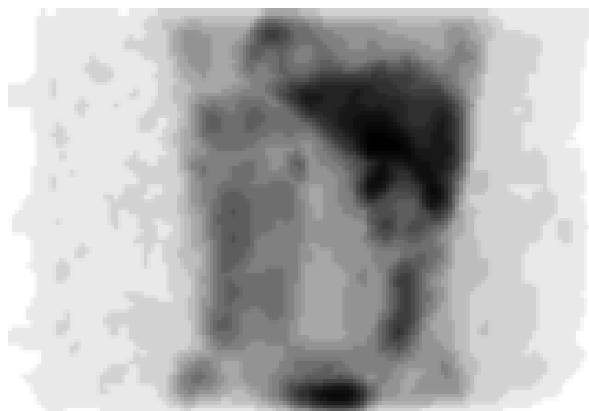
Adrenal gland scintigraphy using ^{123}I -MIBG. Pathological accumulation of activity from the 3rd liver segment through porta hepatis to the caudal, oval shaped, not quite homogeneous aggregation, with “cold” areas - may indicate the presence of pheochromocytoma.
